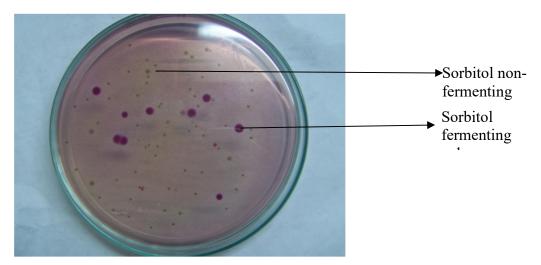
Different types of colonies on CT-SMAC agar plate
